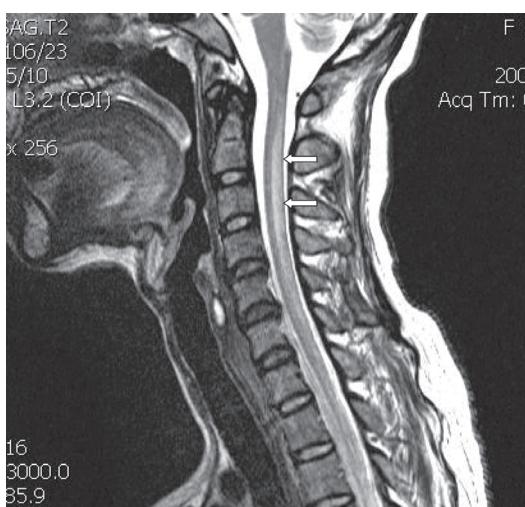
Sagittal plane T2-weighted MRI of cervical spine after injection of gadolinium showing ill defined hypersignal T2 change without focal enhancement extending from C2-C6 level indicates of myelopathy
